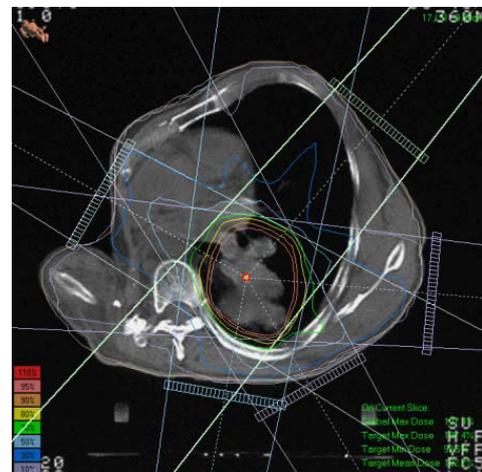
First CT fixed position scan, input TPS planning system, outlined GTV1, made proposal 1.
